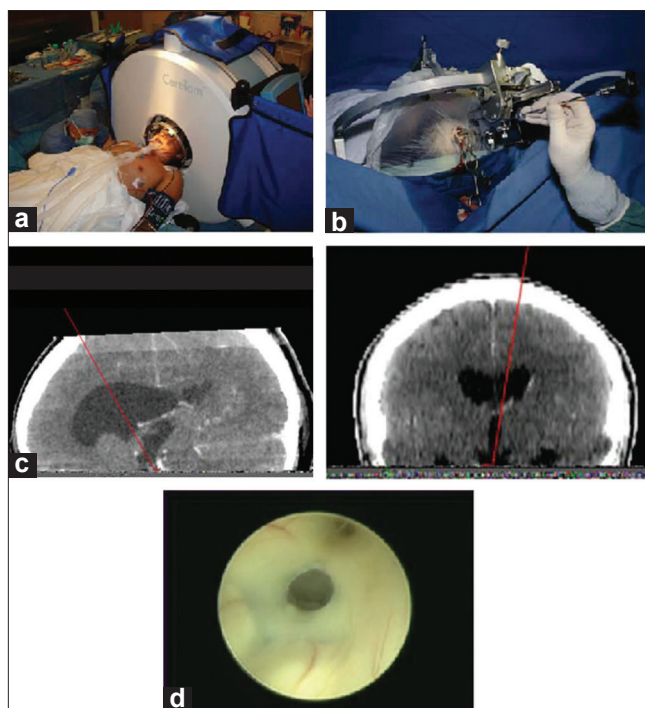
(a) Intraoperative head computed tomography for stereotactic planning of endoscopic third ventriculostomy (ETV) trajectory. (b) ETV performed under stereotactic guidance using the Riechert/Mundinger frame. (c) Stereotactic trajectory with en-face view of the floor of the third ventricle. (d) Completion of ETV
